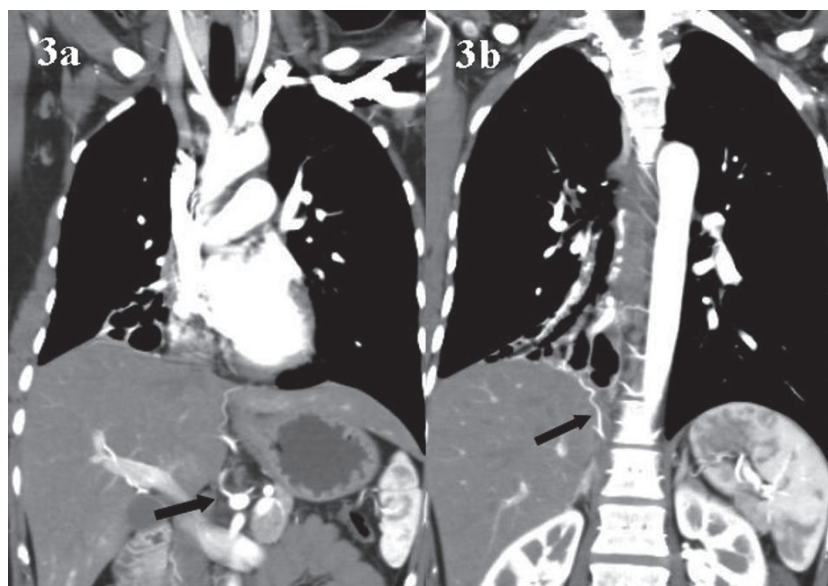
(a) Coronal reconstructive image of thoracic CT scan shows the aberrant vascular structure originating from celiac trunks (arrow). (b) In coronal reconstruction, this vessel extends to the pulmonary sequestration (arrow).
